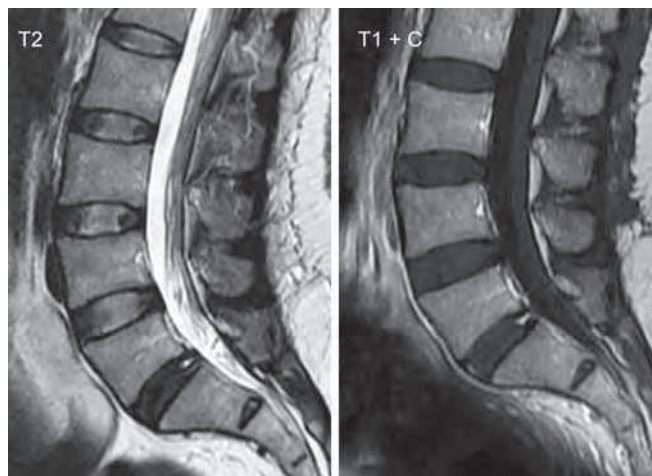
MRI of L5-S1 intervertebral disc with a posterior annular tear with associated degenerative changes, but no cord compression in patient who presented with back and leg pain.
